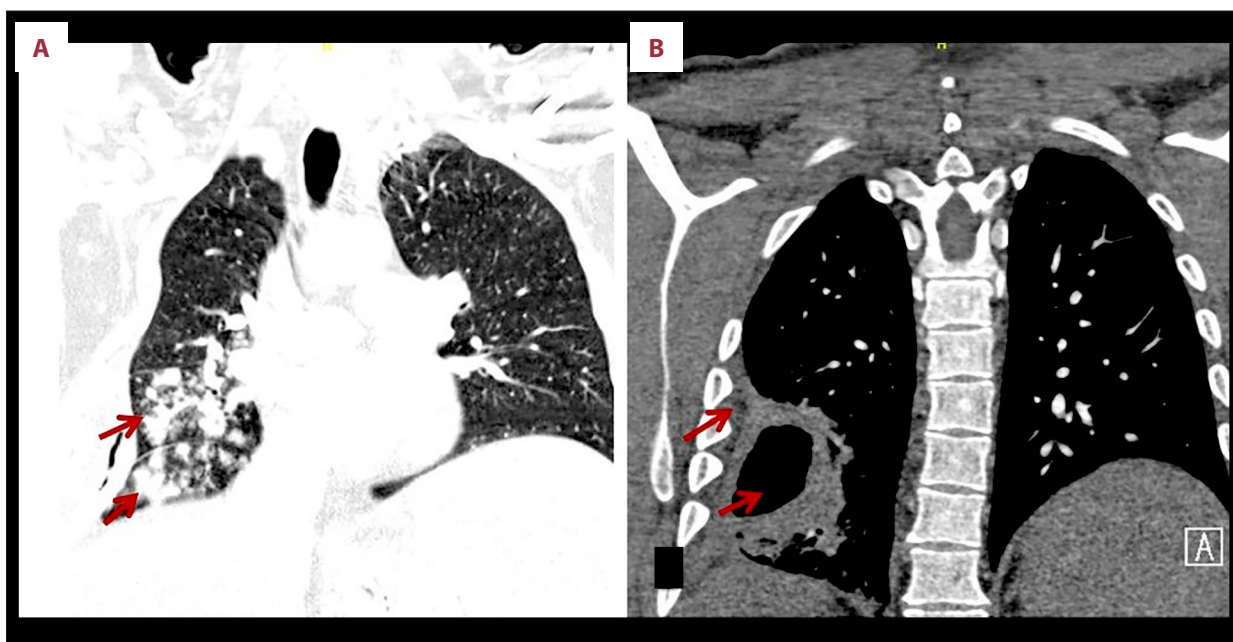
Chest CT shows nodular consolidation in the right middle and lower lobes (arrows) (A). In addition to a loculated right-sided pleural effusion with an air-filled cavity (arrows) (B).
